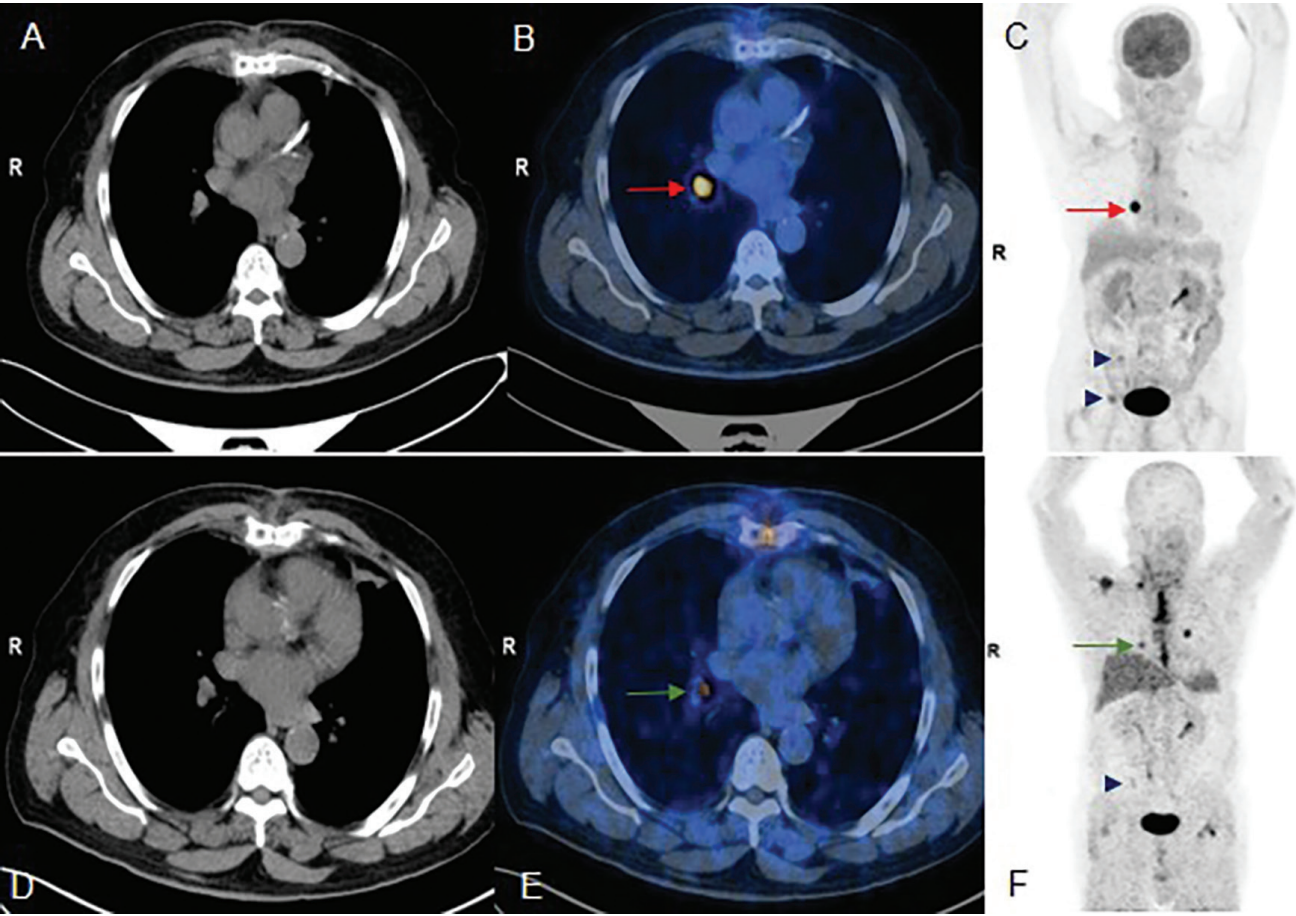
Representative images showing pulmonary metastases. (A, D) axial CT image showing a right lung nodule. (B) Corresponding fused ¹⁸F-FDG PET image demonstrate intense metabolic activity (SUV_{max} 15.9) in the lung nodule (red arrow). (E) Fused ⁶⁸Ga-FAPI-04 PET image show moderate uptake (SUV_{max} 7.3) in the same nodule (green arrow). (C, F) MIP images of ¹⁸F-FDG and FAPI whole body PET show additional foci of increased ¹⁸F-FDG and FAPI uptake in left lung and right lower cervical lymphnode (more prominent on FAPI). Bone lesions in right iliac bone are better appreciable on ¹⁸F-FDG (blue arrow heads)
